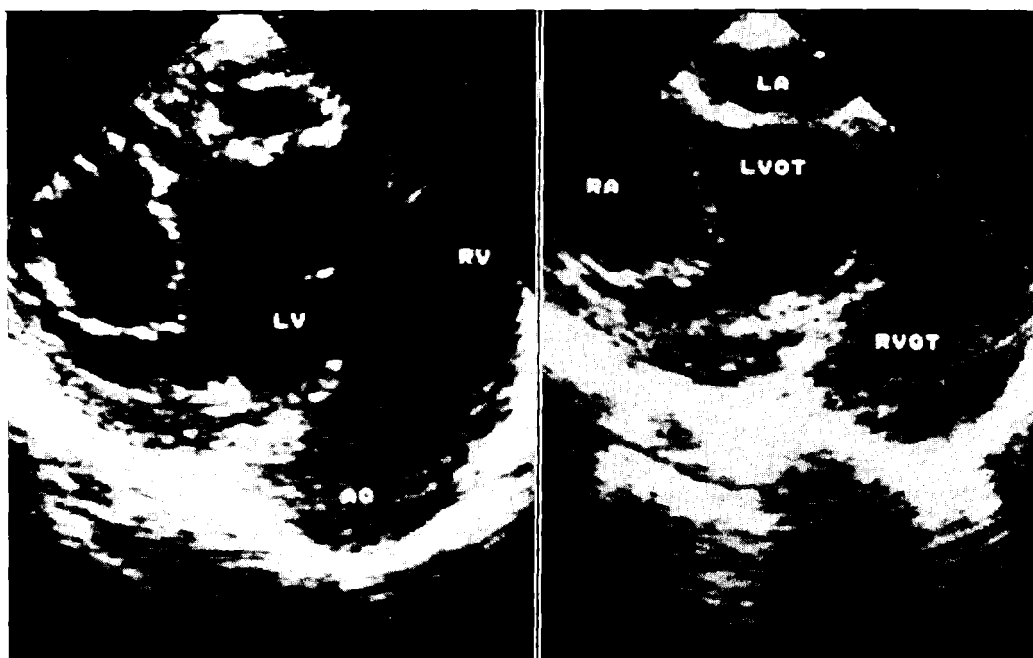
Sequence of transesophageal views in the preoperative evaluation of a child with double inlet of the left ventricle. The chordal attachments of either AV valve and their relation to the ventricular septum and outflow tracts were clearly demonstrated.
